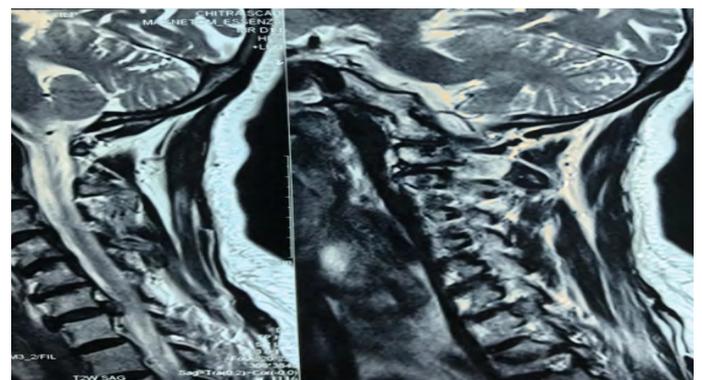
Resonance Imaging (MRI) having unilateral cervical foraminal stenosis or unilateral postero-lateral soft disc herniation.
